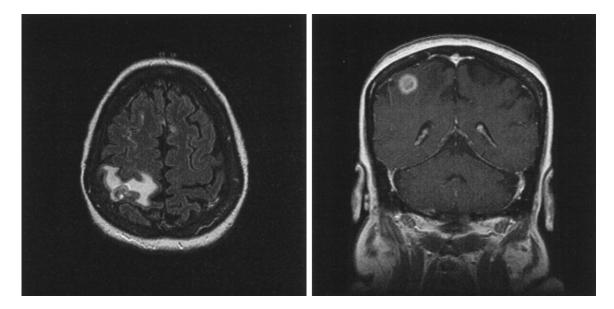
An axial fluid attenuation inversion recovery MRI (*left*) and a gadolinium-enhanced coronal MRI (*right*) of patient 1 show a right parietal, 14-mm rim-enhancing lesion with a hyperintense mural nodule.
